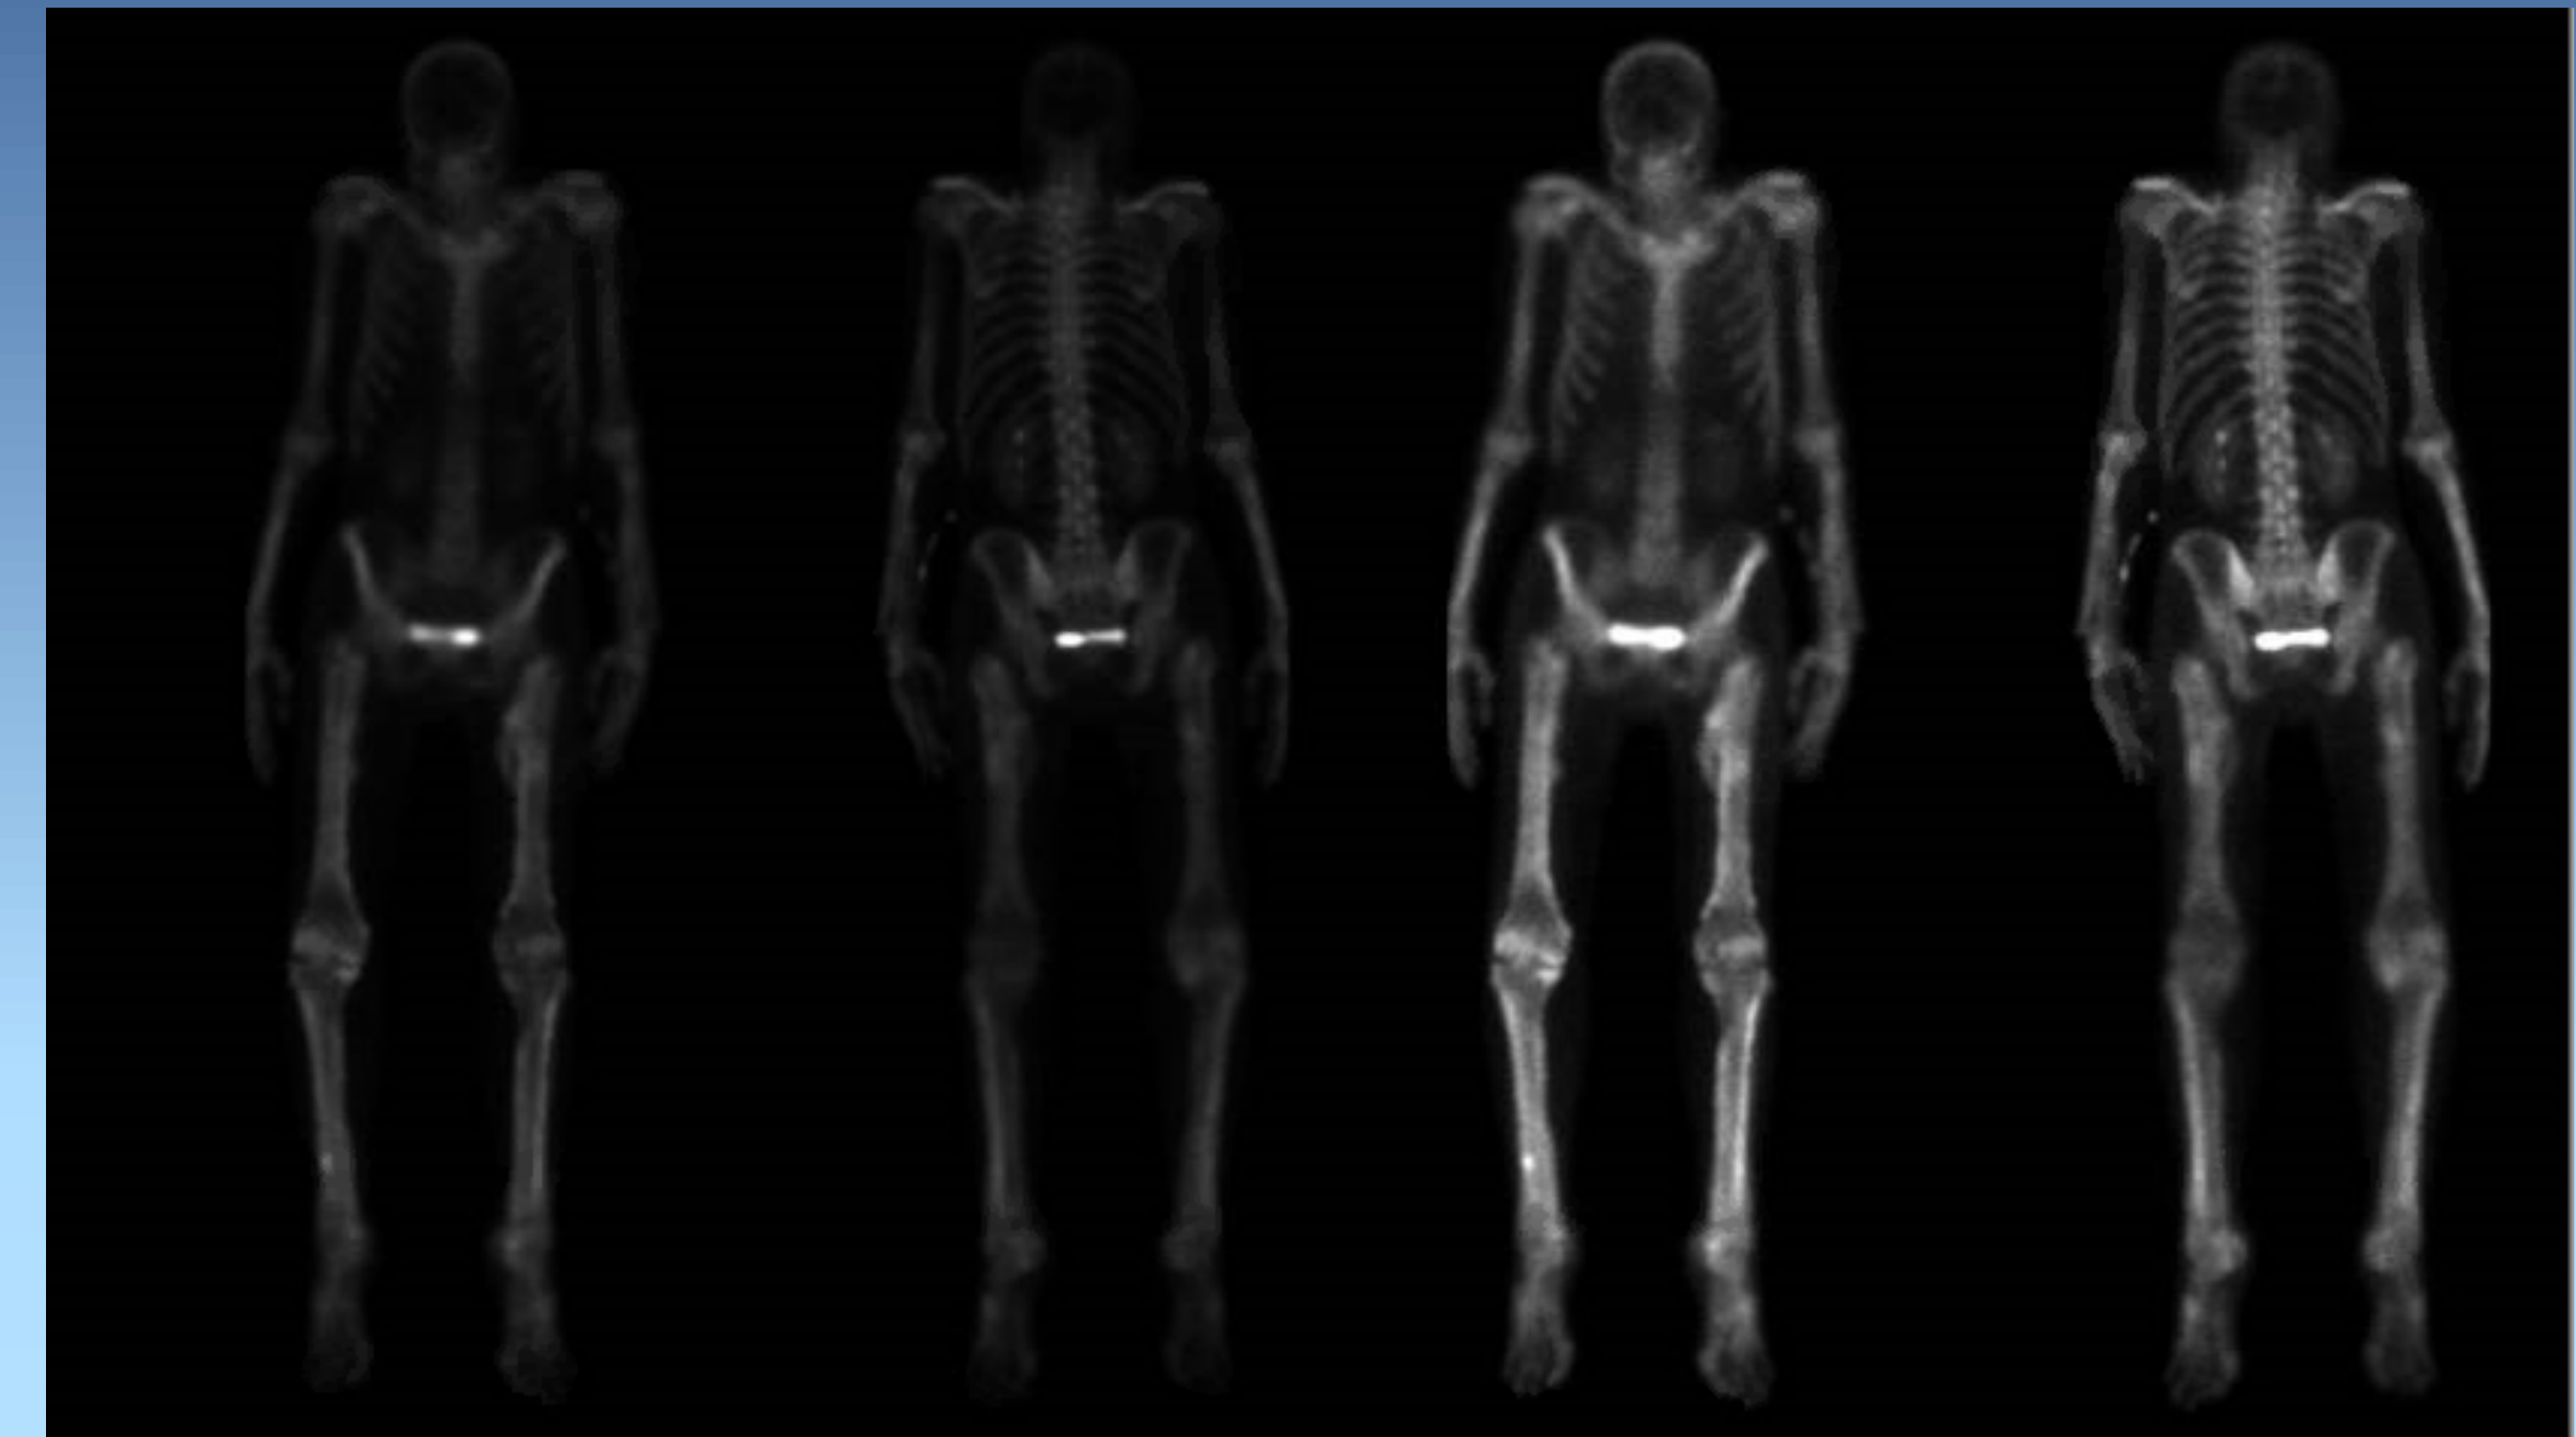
Bone scintigraphy
